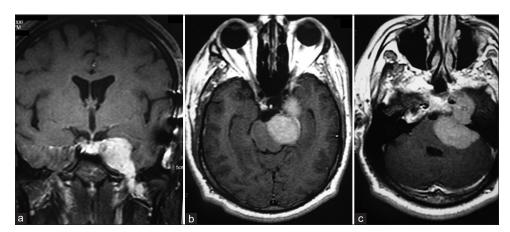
Magnetic resonance imaging preoperated showing expansive lesion in the left petroclival region with left to right mass effect, invading the cavernous sinus with extension into the posterior fossa and reach the cervical region, descending through the petroclival portion, bordering the clivus. Lesion with contrast enhances compatible with meningioma. (a) Coronal gadolinium-enhanced image (GEI). (b and c) Axial GEI.
